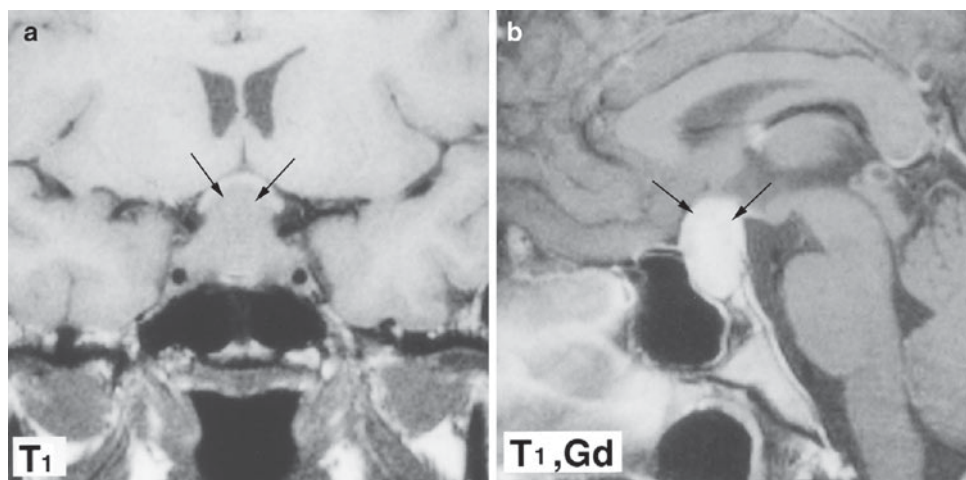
MRI in a patients with lymphocytic hypophysitis. Arrows indicate pituitary gland with lymphocytic hypophysitis. (a) Coronal T1-weighted MRI scan. (b) Sagittal T1 weighted MRI scan after gadolinium enhancement (Reproduced from Takahashi
